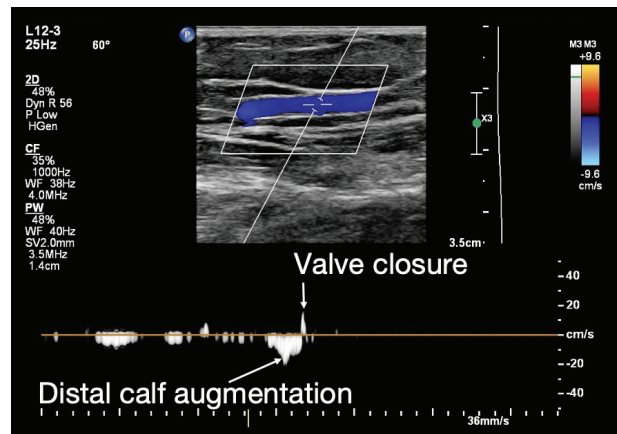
Pulsed-wave Doppler waveform demonstrates a competent GSV with normal valve closure.
